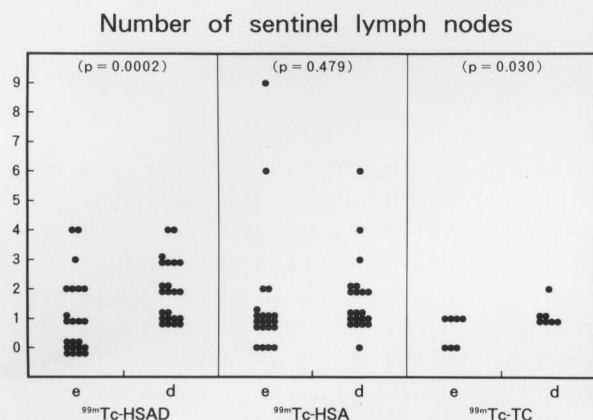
Comparison of the number of SLNs demonstrated in early (e) and delayed (d) images. The mean number \pm standard deviations of SLNs obtained by lymphoscintigrams with ^{99m}Tc-HSAD, ^{99m}Tc-HSA, and ^{99m}Tc-TC were 1.05 ± 1.27 and 1.91 ± 1.0 , 1.52 ± 2.11 and 1.71 ± 1.31 , and 0.57 ± 0.53 and 1.14 ± 0.38 , in early and delayed images, respectively. P value in parenthesis was calculated by the paired t-test between the number of SLNs demonstrated in early and delayed images.
